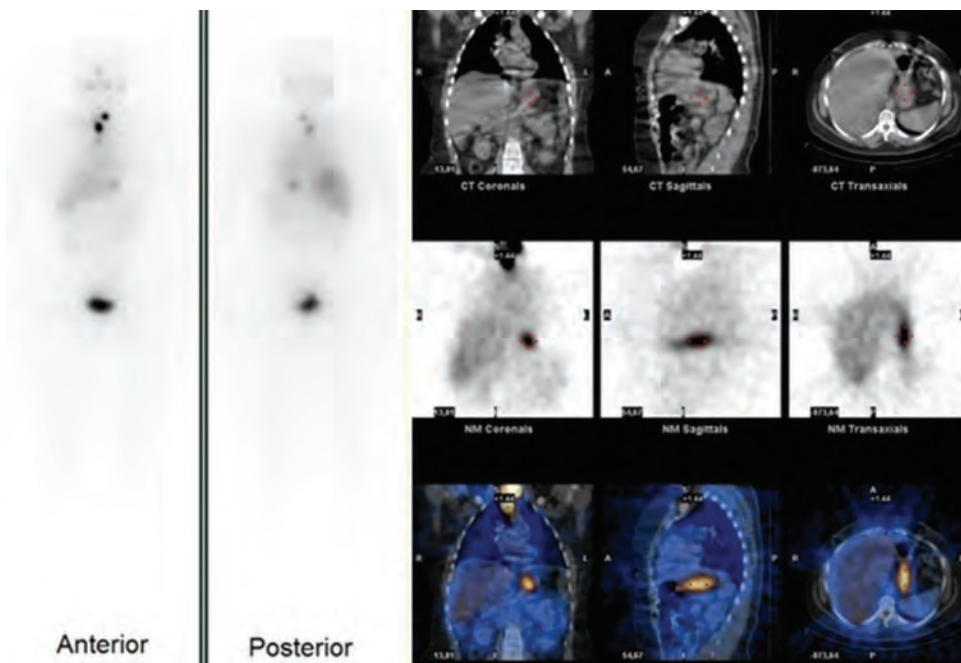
RAI treatment due to the pathology result of papillary carcinoma with capsular invasion and vascular invasion, SPECT/CT imaging was performed due to suspicious RAI involvement in the upper mediastinum compatible with the residual tissue in the thyroid lodge and in the left midline in the abdomen in the WBS performed on the 7th day of the treatment. SPECT/CT images showed an involvement consistent with metastatic LAP in the upper mediastinum, while benign activity involvement consistent with the stomach was observed in the left midline of the abdomen. With SPECT/CT, in this case one suspect involvement was reported as malignant and one suspicious involvement was reported as benign
